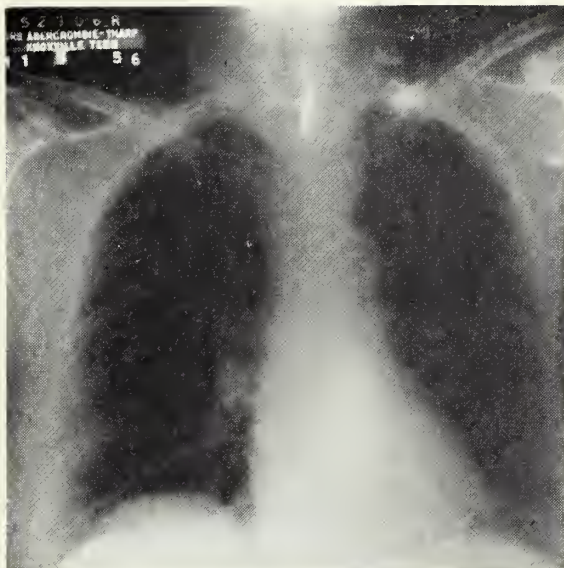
M. N. Postoperative P. A. roentgenogram showing normal findings.
